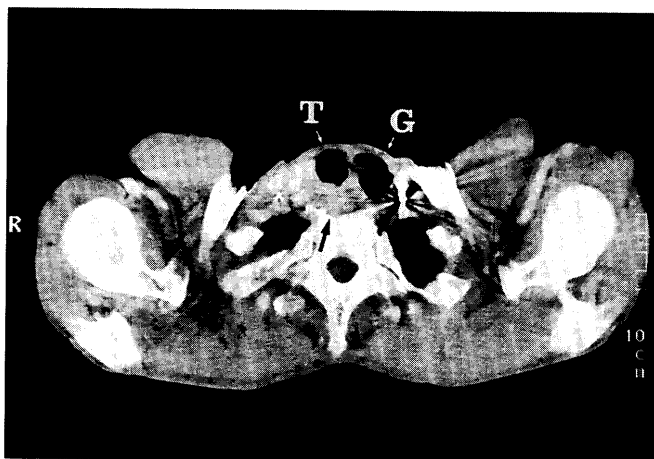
CT showing a metastatic tumor (*arrow*) at the right side of the trachea. T and G indicate the trachea and gastric tube, respectively.
